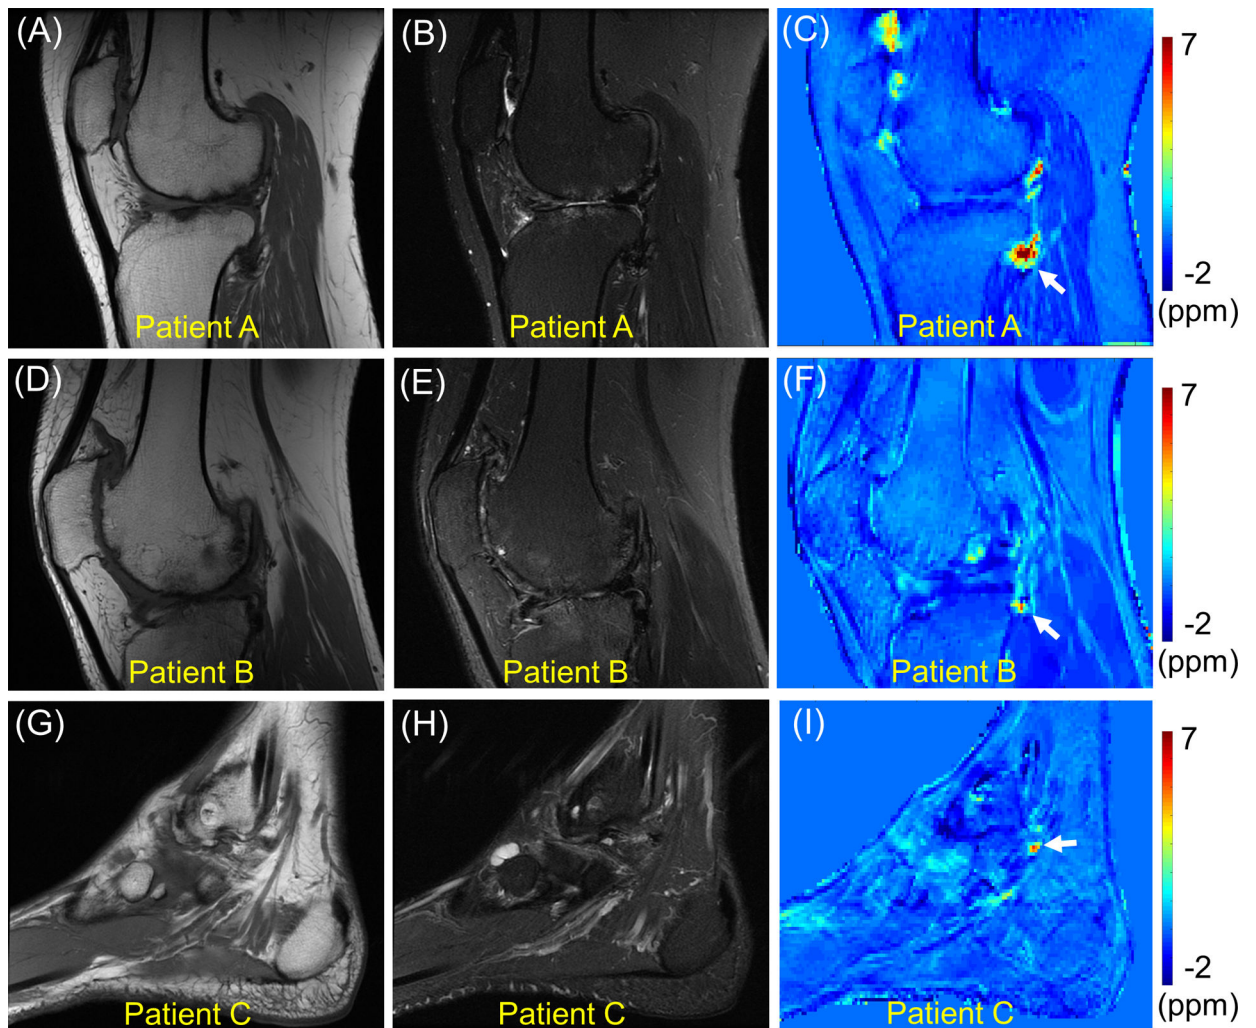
Clinical MR images and QSM in all three hemophilic patients. T1-weighted MRI (A, D, G), T2-weighted MRI (B, E, H), and QSM (C, F, I). The susceptibility estimated in the regions of interest indicated by white arrows are 4.9 ± 2.5 ppm, 2.4 ± 1.6 ppm, and 2.3 ± 1.9 ppm for Patients A, B, and C, respectively.
